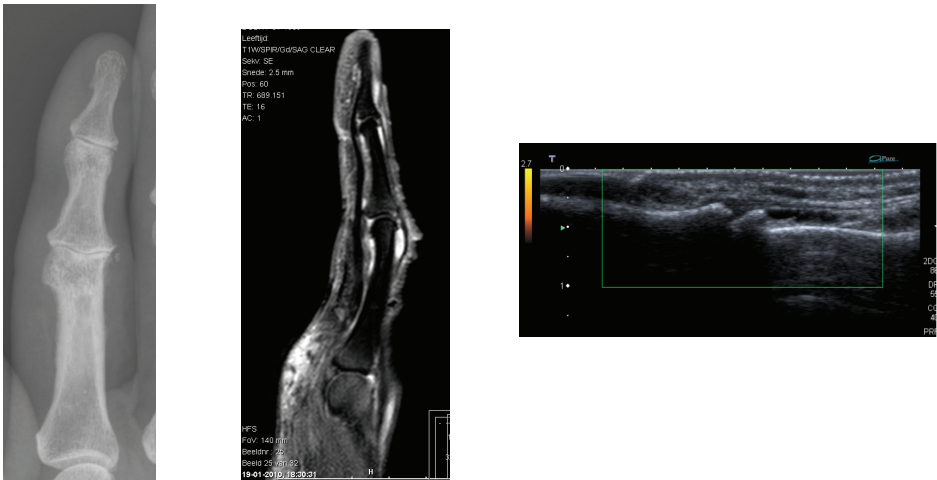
Images of the second finger of the right hand of an OA patient. On the left the radiograph of the same finger. In the middle a T1 weighted sagittal MRI image with gadolinium enhancement showing synovitis and on the right the ultrasound image of the DIP joint showing an osteophyte, effusion and synovial thickening.
